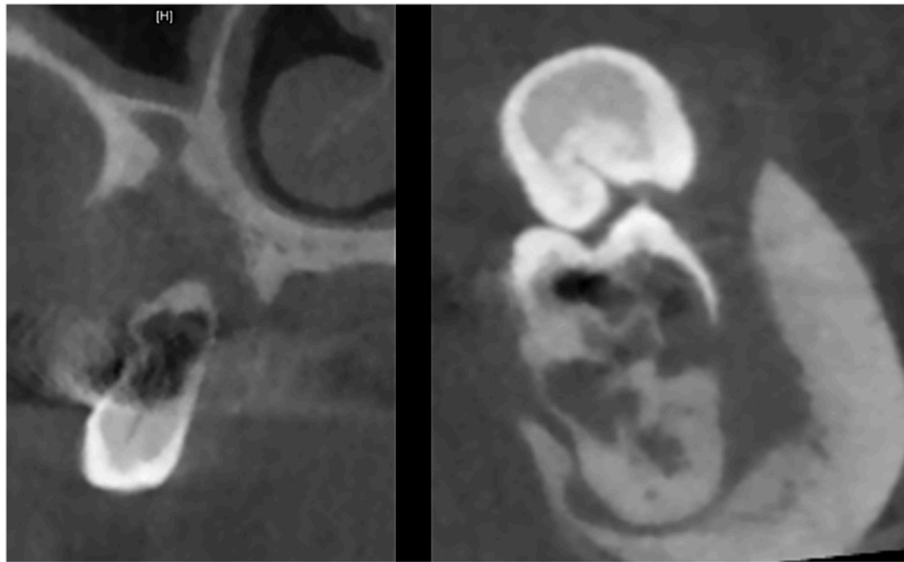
Severe resorptions detected in the teeth affected by primary failure of eruption (computed tomography images).
